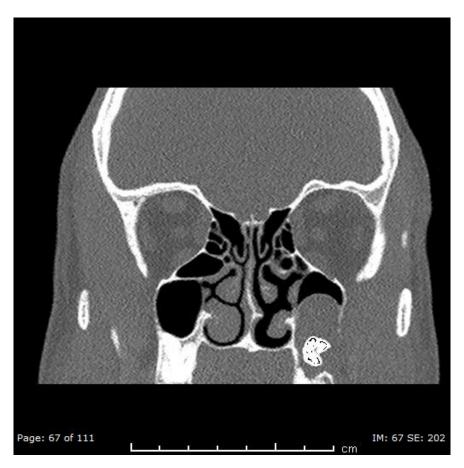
CT scan of dentigerous cyst involving the maxillary sinus
